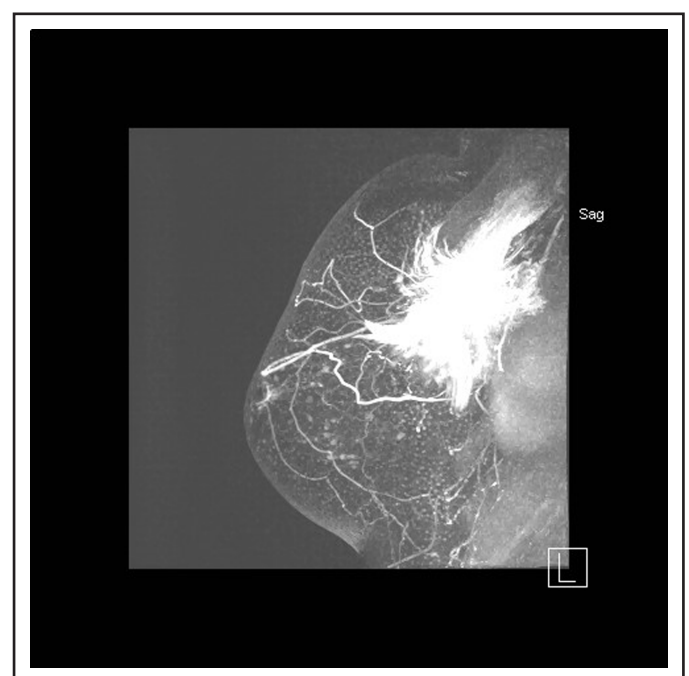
T1-weighted post-gadolinium dynamic image. Enhancement beyond the scar.
